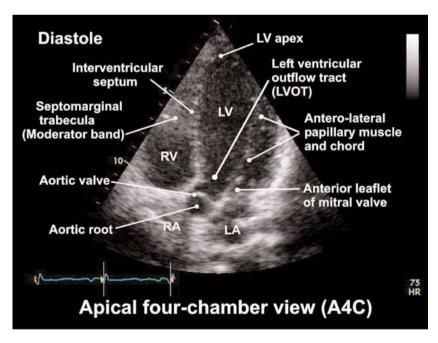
Annotated apical five-chamber (A5C) view.
